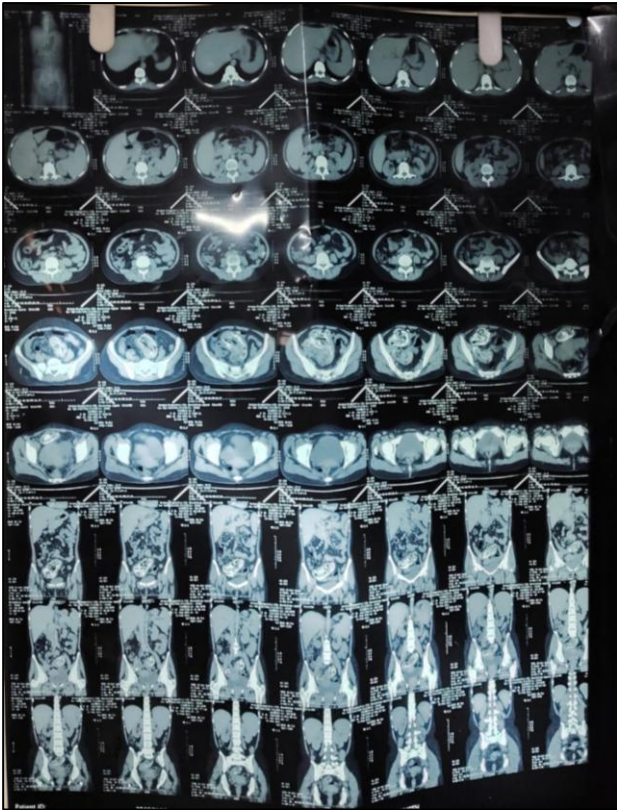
Contrast-enhanced CT scan showing a spongiform intraluminal mass with internal air foci in the terminal ileum, indicative of a retained surgical sponge.
